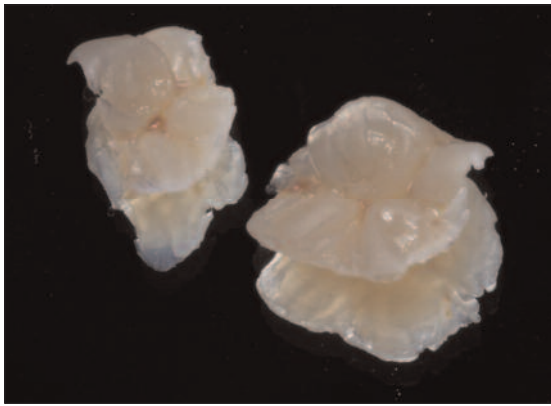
Onlays removed from model, air abraded with 27 micron alumina and cleaned in an alcohol ultrasonic bath
